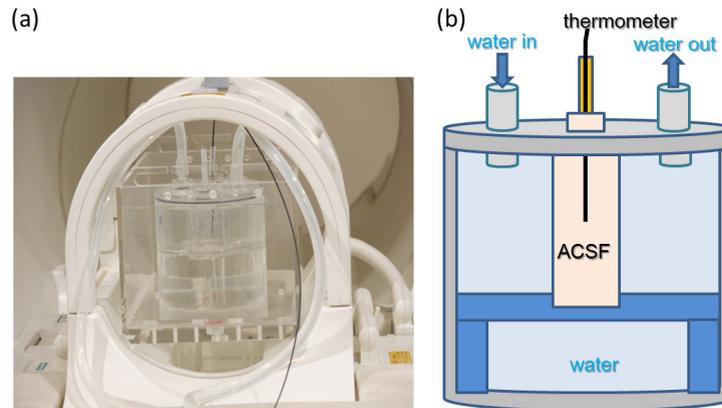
Water-jacket-style thermal maintenance equipment. (a) Set in head coil of MRI scanner. (b) Graphical representation of the equipment.
